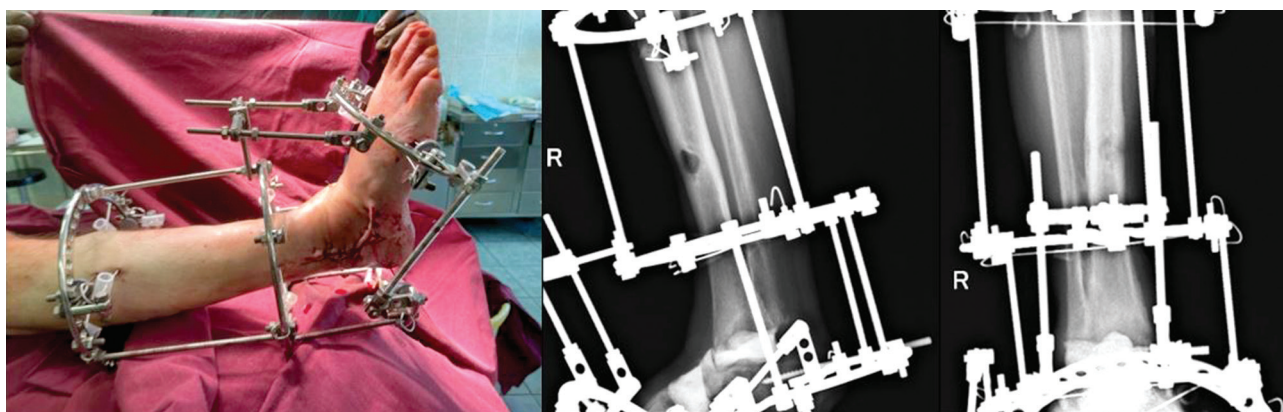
Photo and radiographs capturing the tibia and foot after the first stage
